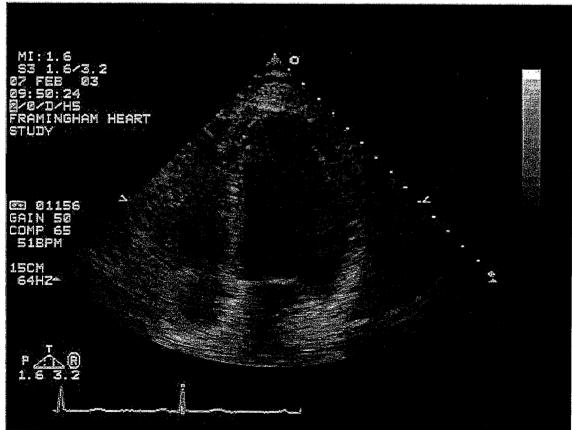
Example of 2-D Apical Four-Chamber view. The image is off-axis with unclear definition of the endocardium. The right atrium and ventricle are not fully open (suboptimal image).
